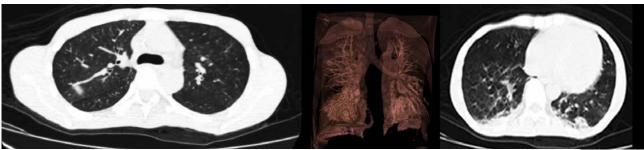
Multislice spiral CT of the lungs of 09.10.2014 in patient G.: some of the foci became more dense, some others resorbed; the emerging pneumonia can be visualized in the lower-posterior segments of the lungs
